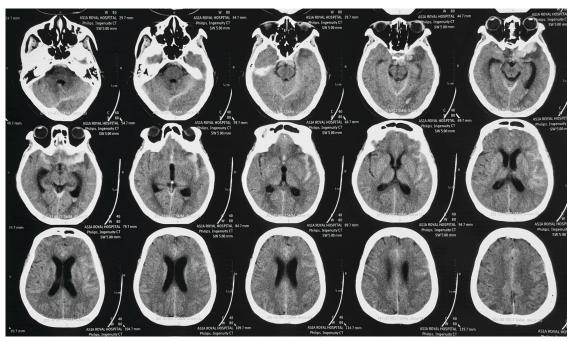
Head CT indicating diffuse SAH, Fisher grade 2.
